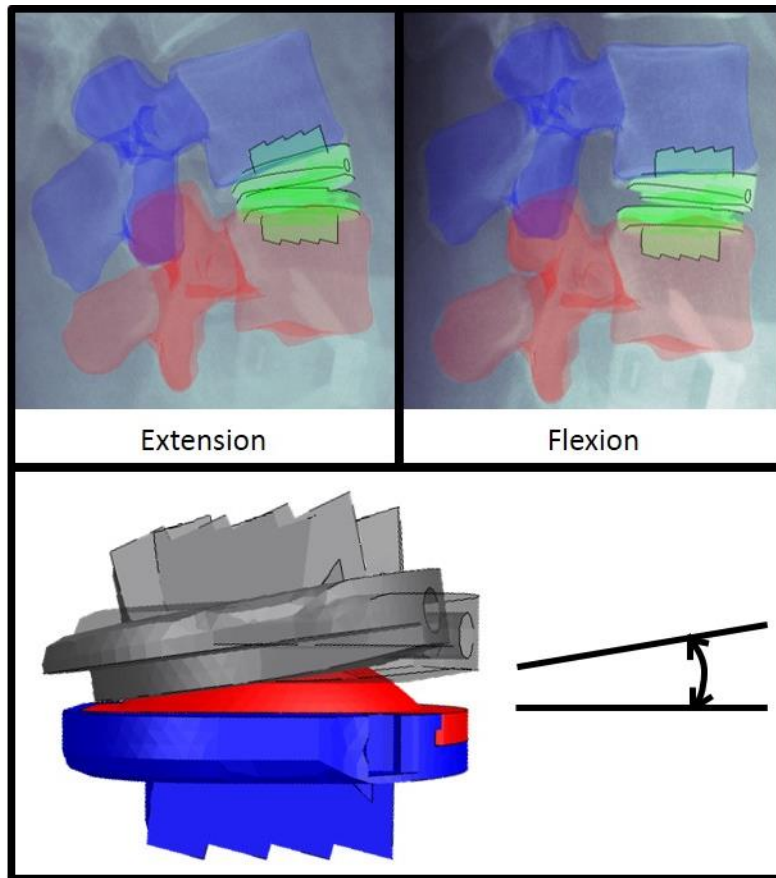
Three-dimensional model overlay with flexion-extension x-ray images. Change in angle measured from resulting 3D model.
